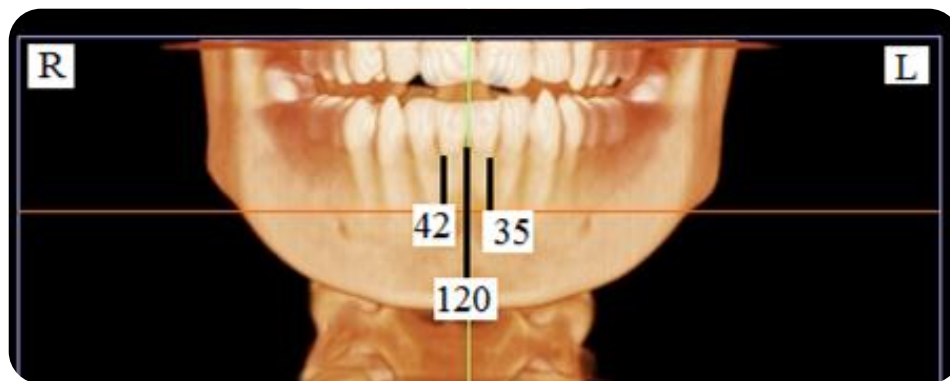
The frequency and percentage of Lingual Canal location in relation to the midline in 200 images (Note that there were no lingual canals detected in 3 images). (Images obtained with i-CAT® Model 17-19; CBCT Imaging Unit: InVivoDental5 Version 5.2 Anatomage, software): Dentomaxillofacial Radiology Department; Faculty of Dentistry, University of Yeditepe.
